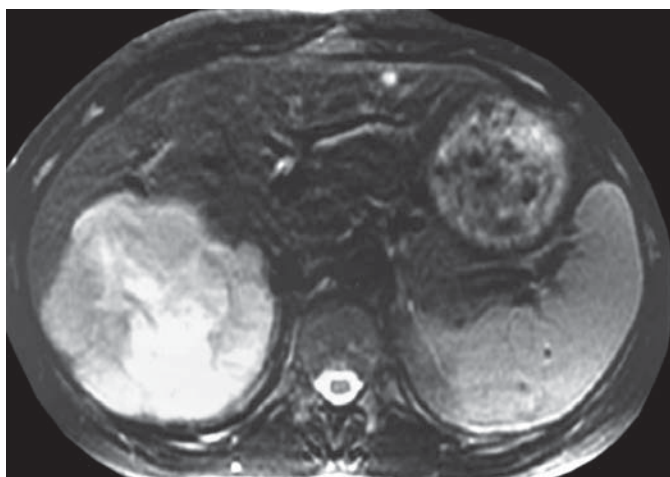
T₂-weighted MRI of giant haemangioma replacing much of right posterior sector.
